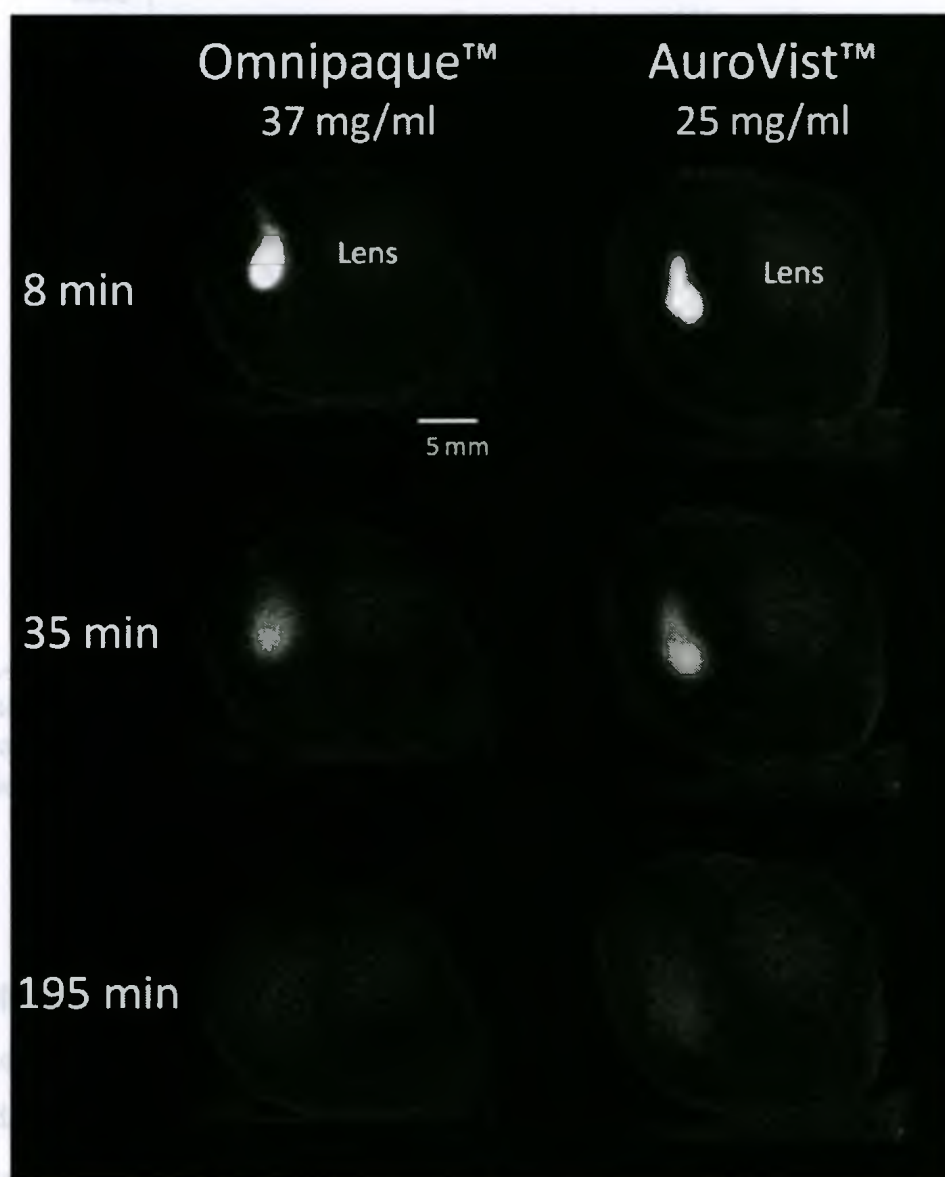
CT scan slices showing contrast agent in vitreous at time steps
